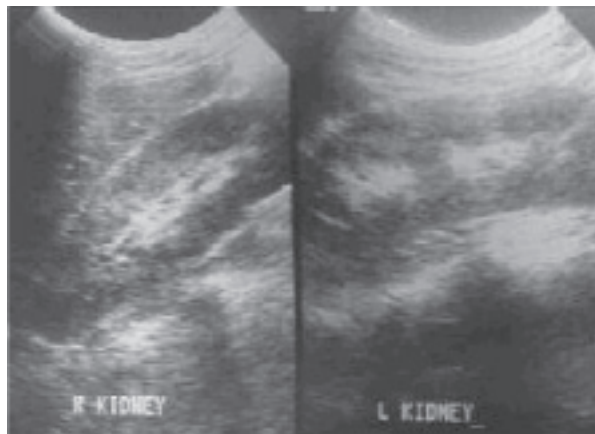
Abdominal ultrasound showed a progressive reduction in size of both kidneys at 3rd weeks after the initial diagnosis.
